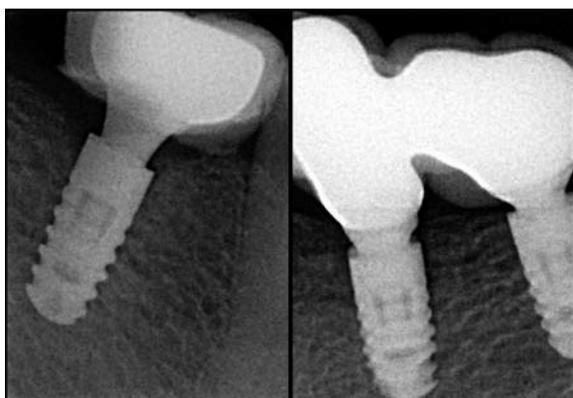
Posttreatment x-rays
